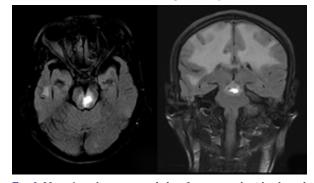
28yrs female post natal day 2 presented with altered sensorium MRI FLAIR Axial and coronal section showed acute pontine bleed with minimal surrounding edema
